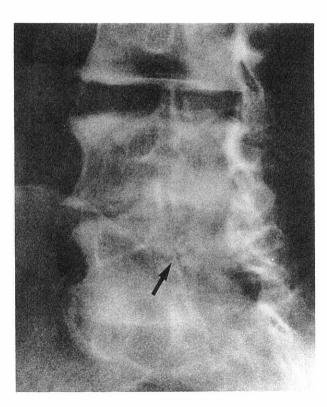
Case 1: Right posterior oblique lumbar spine radiograph of 7 November 1975 shows a new right-side pars interarticularis defect (arrow) of L5
